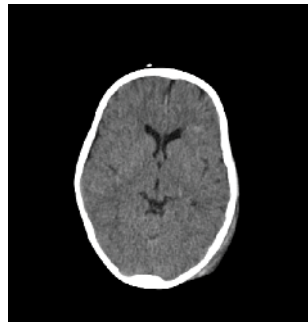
CT brain showing subarachnoid haemorrhage and multiple cerebral microbleeds.
